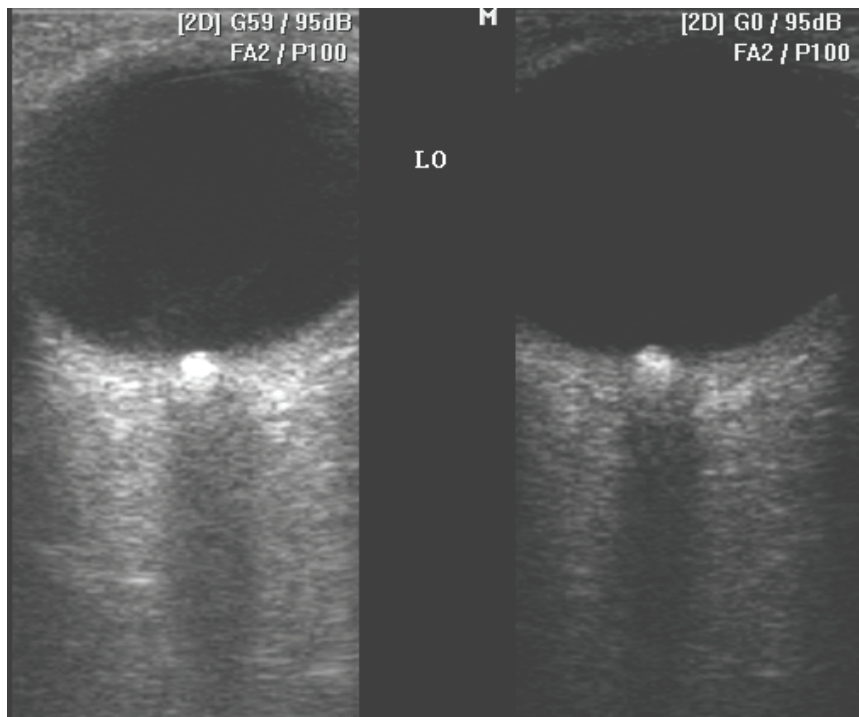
Left: Optic disc drusens B-scan ultrasonography in standard mode – gain 59 dB. Right: “halo” effect of optic disc drusens is minimised (drusens display in actual size) when gain is reduced to 0 dB.
